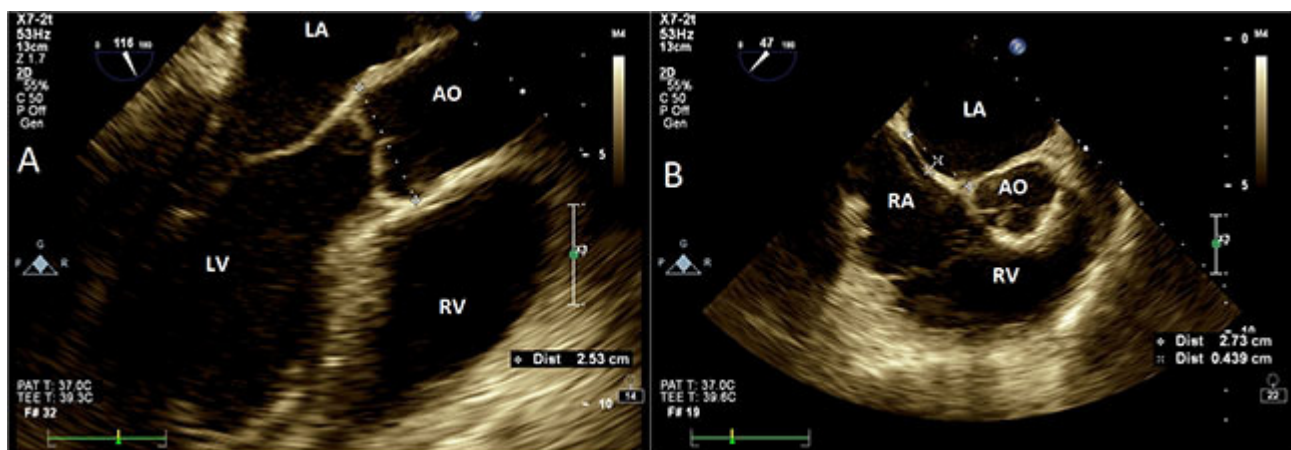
Transesophageal echocardiography. (A) Aortic measurements at Valsalva sinus plane (120°, mid-esophageal view). Aorta measured at leading edge echo signal of posterior wall to the leading edge of anterior wall. (B) Interatrial septal size and oscillation (25–45°, mid-esophageal view) measured as the maximal perpendicular distance from an imaginary line drawn between atrial septal insertion points (dashed line). AO, aorta; LA, left atrium; RA, right atrium; LV, left ventricle; RV, right ventricle.
